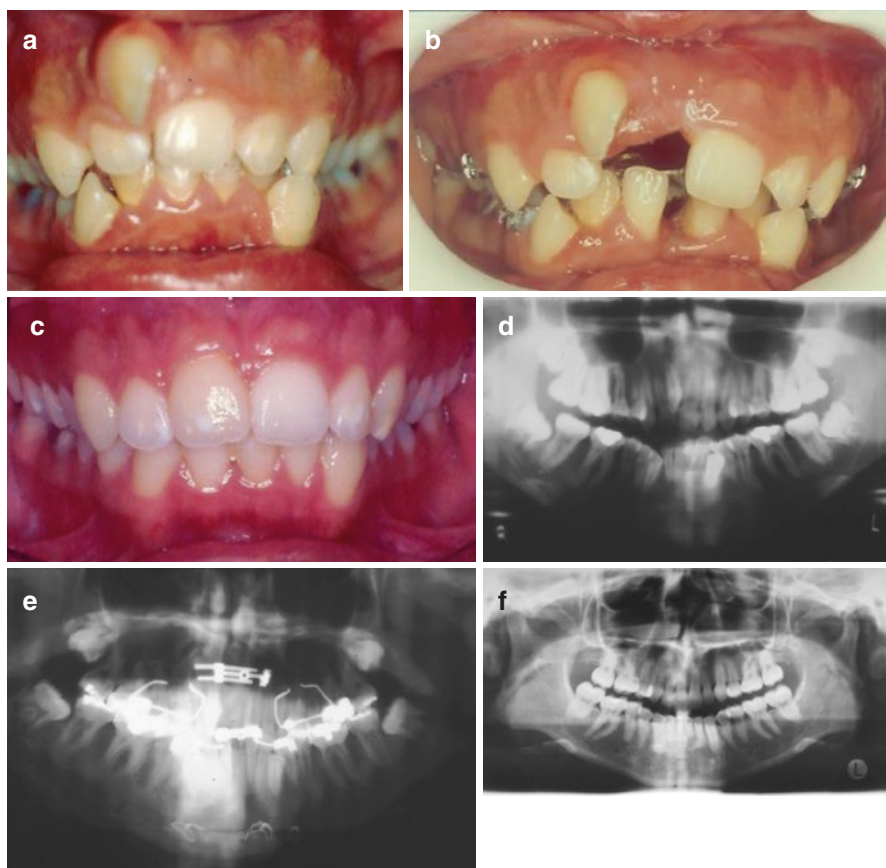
Same patient as in Fig. 5.1. Space was created for descent of the right upper central incisor. Progressive maxillary expansion dictated simultaneous mandibular widening. (a) Pretreatment intraoral view. (b) Intraoral view during activation. (c) Posttreatment intraoral view. Note the satisfactory occlusion; a lower central incisor was removed secondary to Bolton's discrepancy. (d) Pretreatment panoramic radiograph. (e) Panoramic radiograph during treatment (f) Posttreatment panoramic radiograph 25 years later
